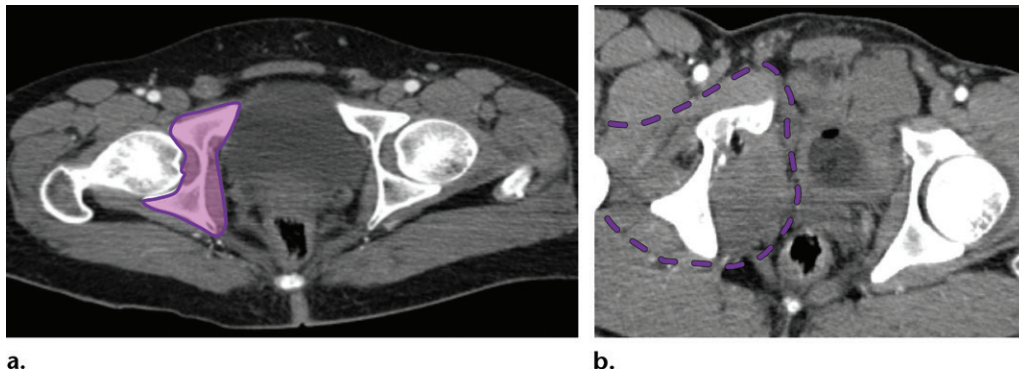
Obturator artery in two patients. (a) Axial CT image in a 25-year-old man at the level of acetabulum shows the vascular territory of the obturator artery, which supplies the muscles around the hip joint (pink shaded area). (b) Axial CT image in a 45-year-old man at the level of the obturator foramen shows a pelvic hematoma in the obturator internus muscle (dashed outlined area).
